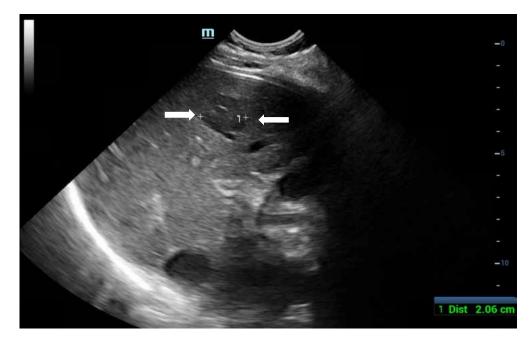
Completely visible nodule on ultrasound
